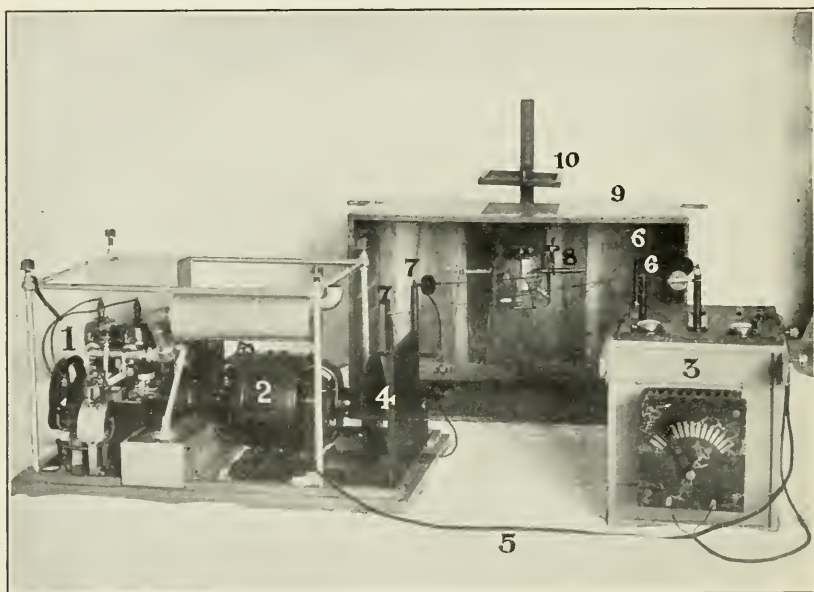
Type of field X-ray apparatus with marine engine. 1, Engine; 2, motor; 3, transformer; 4, rectifying switches; 5, cable containing wires for circuit from motor to primary of transformer and return; 6, secondary terminals of transformer; 7, terminals through which current is carried from rectifying switches to X-ray tube; 8, X-ray tube; 9, packing box utilized as table; 10, plate holder.
